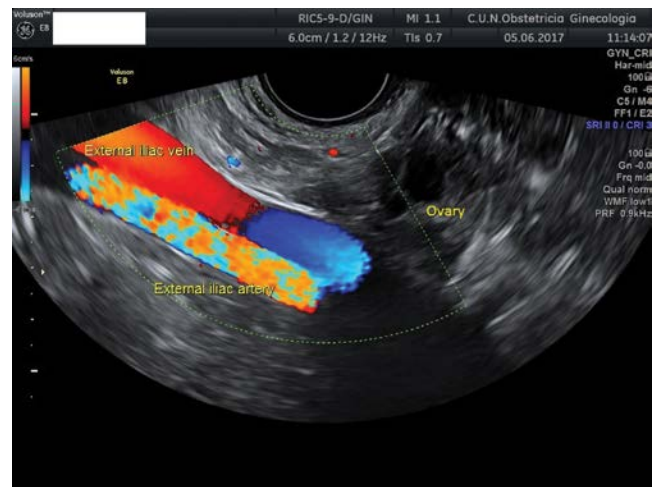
Transvaginal ultrasound showing right external iliac vessels. The ovary is seen lying over these vessels.
